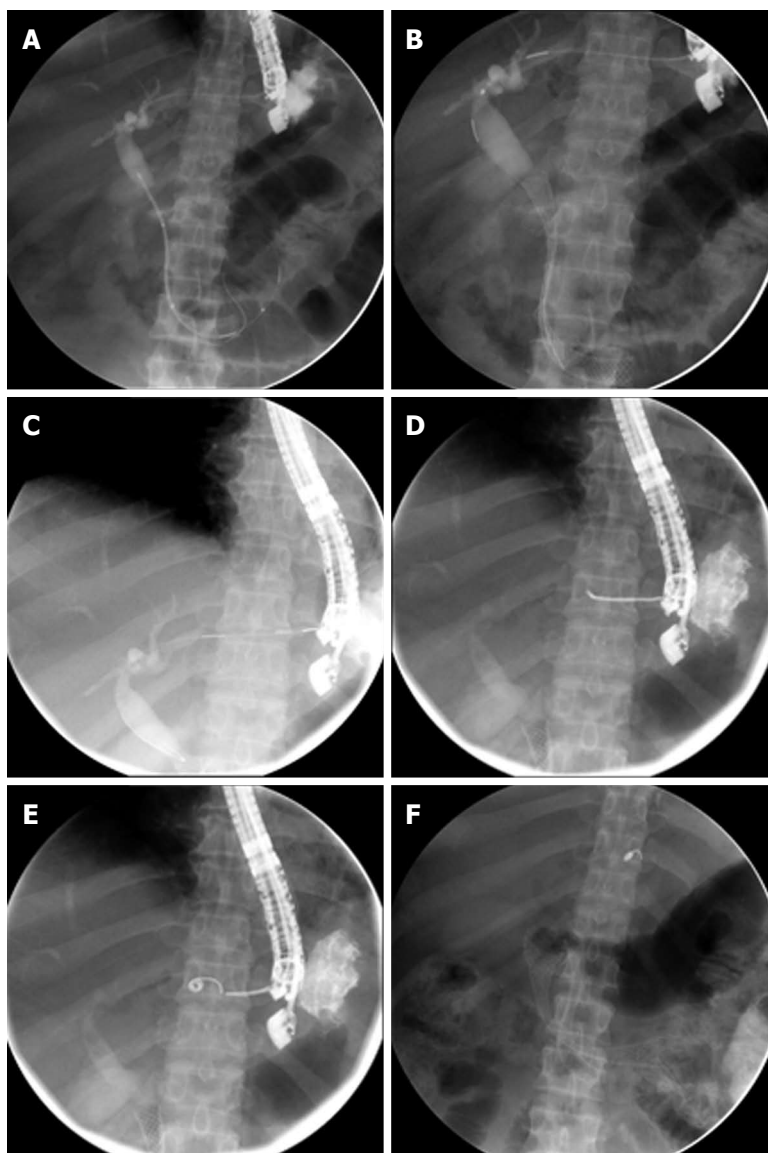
Endoscopic ultrasound-guided biliary drainage followed by endocoil placement. A,B: After successful endoscopic ultrasound cannulation of segment 3 duct a guide wire is passed into the duodenum, the stricture dilated and a 10 mm × 80 mm uncovered biliary stent deployed; C: Next the catheter is withdrawn with the guide wire still in place; D, E: Finally the guide wire is removed with the catheter in position in the track between the dilated segment and the liver capsule an endocoil is advanced and deployed using a standard 0.035 guide wire; F: The final result is shown after stenting of the stricture in the duodenum, showing the biliary stent, duodenal stent and endocoil.
